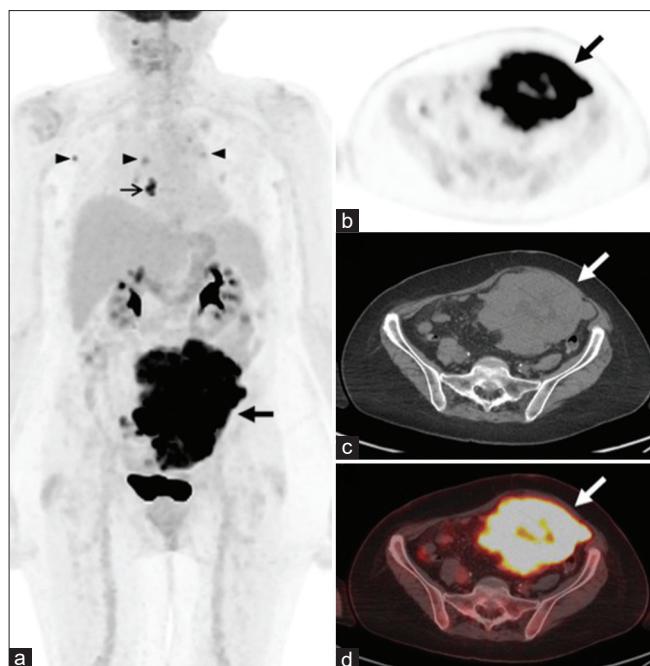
Maximum intensity projection (a), axial positron emission tomography (b), axial nonintravenous contrast-enhanced computed tomography (c), and axial fused positron emission tomography/computed tomography (d) demonstrated an intensely hypermetabolic mass (maximum standardized uptake value: 47) in the left lower quadrant involving loops of small bowel with central foci of necrosis (arrows). Additional foci of uptake in a chest wall inflammatory skin lesion (line arrow) and nonenlarged reactive-appearing thoracic nodes (arrowheads) were noted
